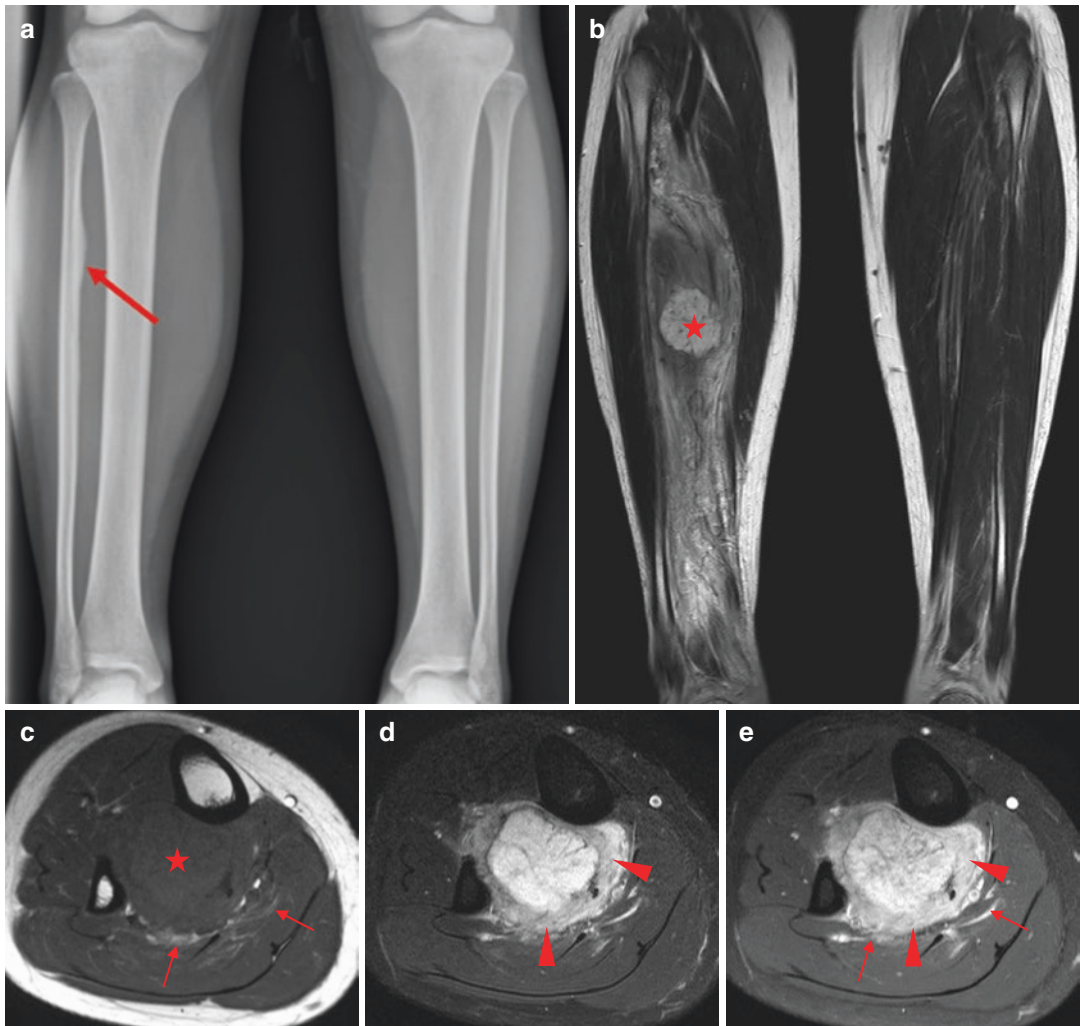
Kaposiform hemangioendothelioma. Radiograph (a) shows diffuse soft tissue swelling of the right lower leg. Note the localized cortical hypertrophy (*arrow*) on the medial aspect of the proximal fibula. Coronal T2WI (b) reveals a central multilobulated, hyperintense soft tissue mass (*star*) with tubular signal voids within the tibialis posterior muscle, which is craniocaudally swollen and exhibits tortuous, dilated flow voids. The tumor is isointense to muscle on T1WI (c), bright hyperintense on T2WI (d), and strongly enhancing on postcontrast FS T1WI (e). The affected muscle (*arrowheads*) has an intermediate signal on T2WI, with less prominent enhancement than the tumor.
